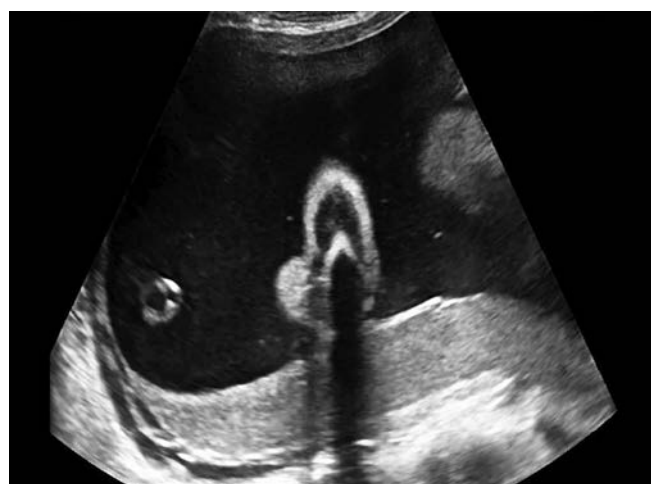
Transverse ultrasound scan revealing central axis of the heart compressed between the enlarged echogenic lungs
